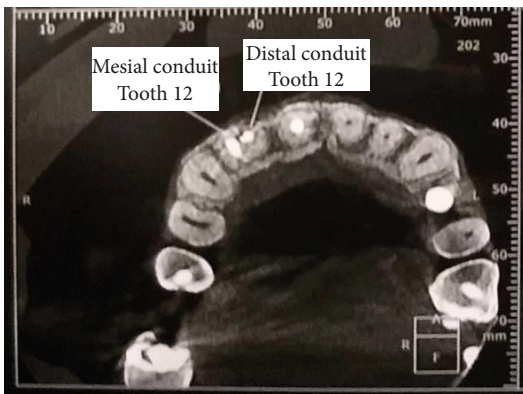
Axial volumetric computed tomography image showing the presence of two conduits in tooth 12.
